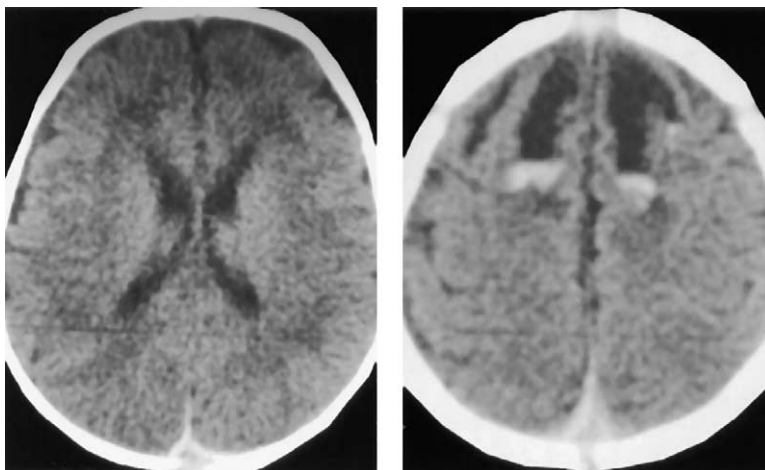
Axial CT scans of young victim of nonaccidental trauma demonstrates subtle subdural hematoma posteriorly, and along the inner atmospheric fissure posteriorly (*left*). More cephalic images demonstrate the hemorrhagic contusions with fluid levels again consequent to the trauma (*right*).
